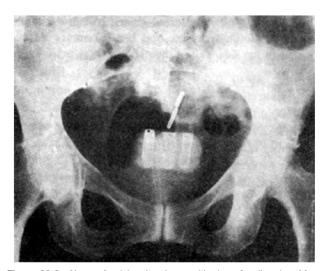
X-ray of pelvis, showing positioning of radium in a Manchester insertion. Note that the central opacity between the two ovoids is, in fact, a space and not a third radium-containing ovoid. (Source: From: Macleod and Read, Gynaecology. 5th ed. Churchill, 1955.)
